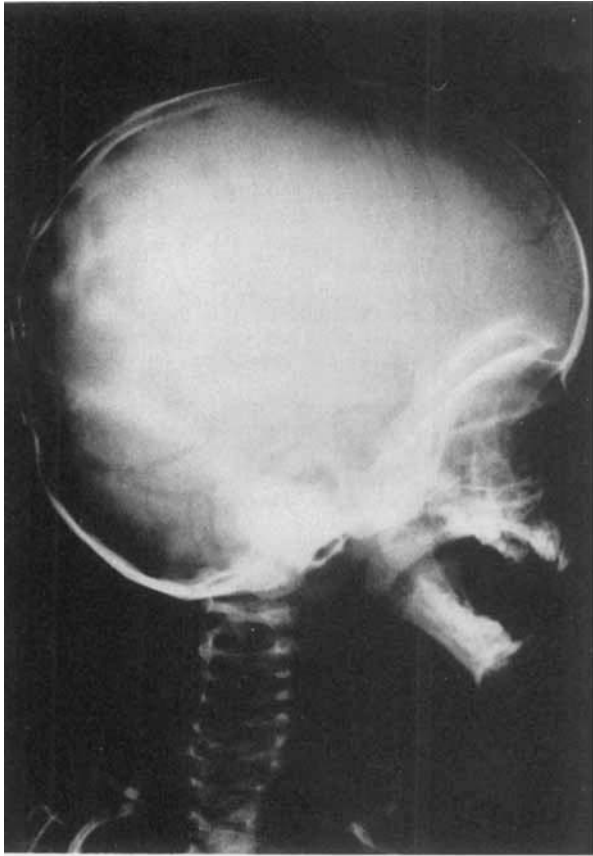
Skull roentgenograph. Note the enlargement of the sella turcica.
